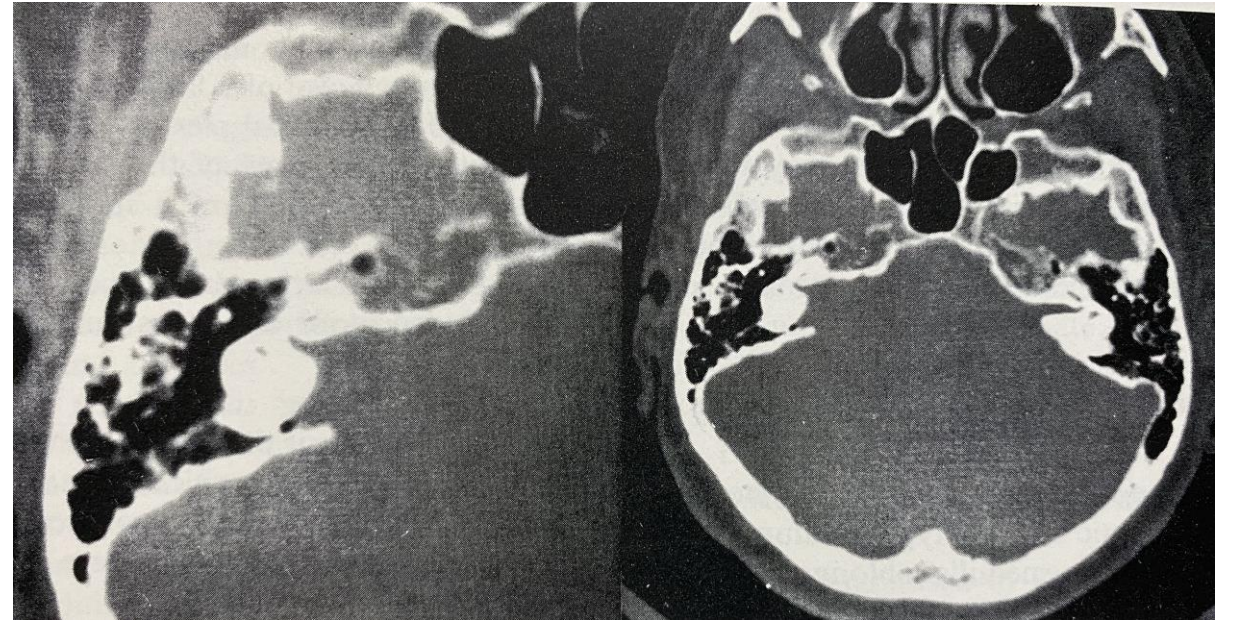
D 3.2. Acoustic neurinoma of the right side in a 50-year-old man with a 3-year history of progressive hearing loss and tinnitus in the right ear. CT:
